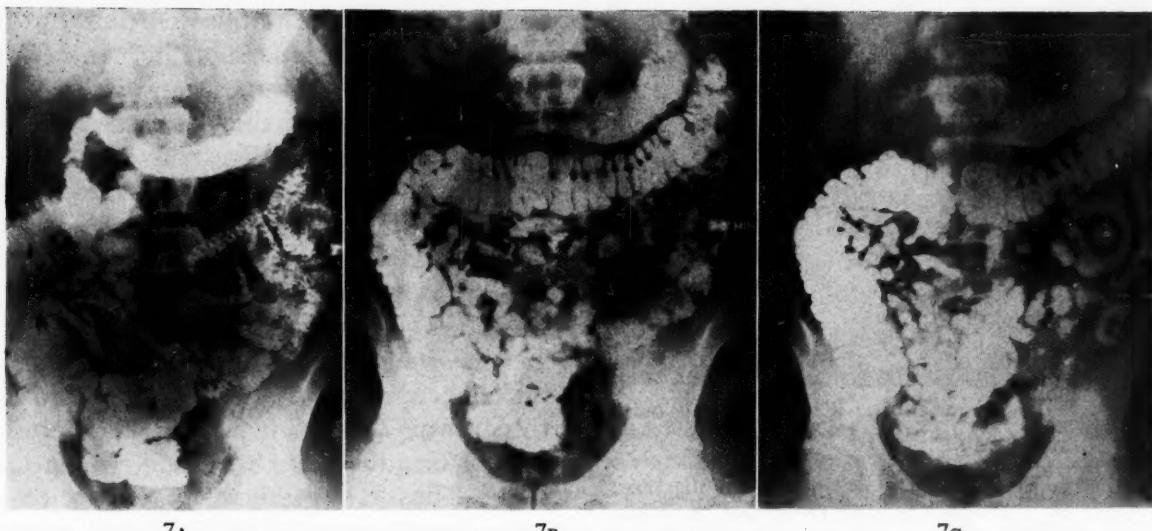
Case II, A, x-ray seventy-five minutes after administration of plain barium meal; there was a normal small intestinal pattern with a continuous stream of barium from the stomach to the terminal ileum; B, thirty minutes after ingestion of clams: there were segmentation of the loops, a suggestion of coarsened mucosal folds, hypertonicity and irregularity of the caliber; the head of the column at the splenic flexure; C, thirty minutes later there was no progress or change.
